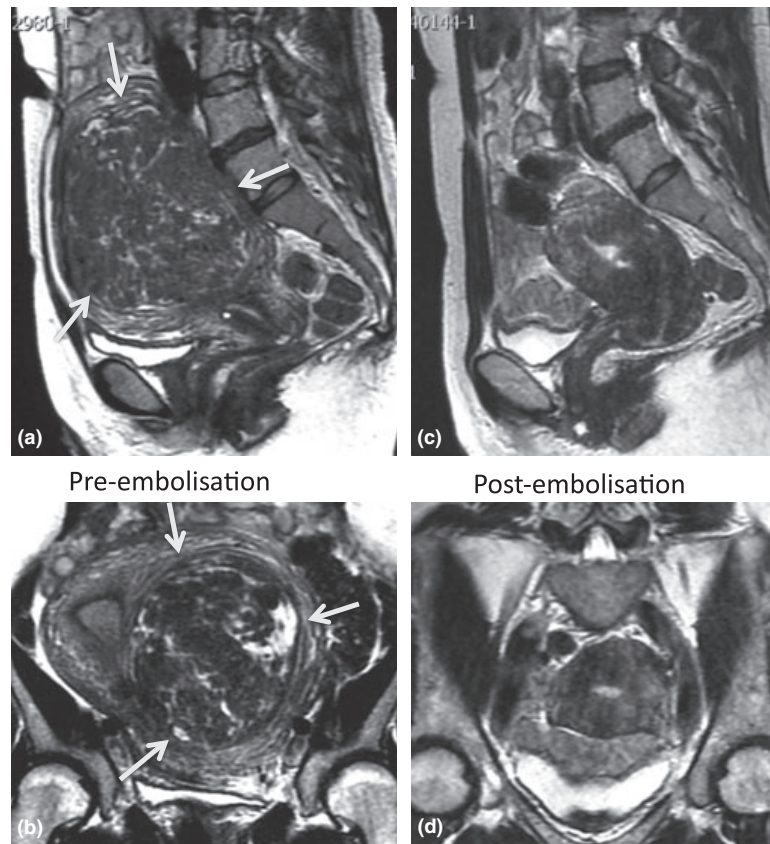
Typical MRI appearance of a fibroid pre- and post-UFE. On the sagittal (a) and coronal (b) T2-weighted pre-UFE MRI images, the fibroid was measured. Note reduction in size and signal on the corresponding six-month post-UFE MRI images (c, d). The fibroid volume reduced 53%, from 658 to 308 mL.
